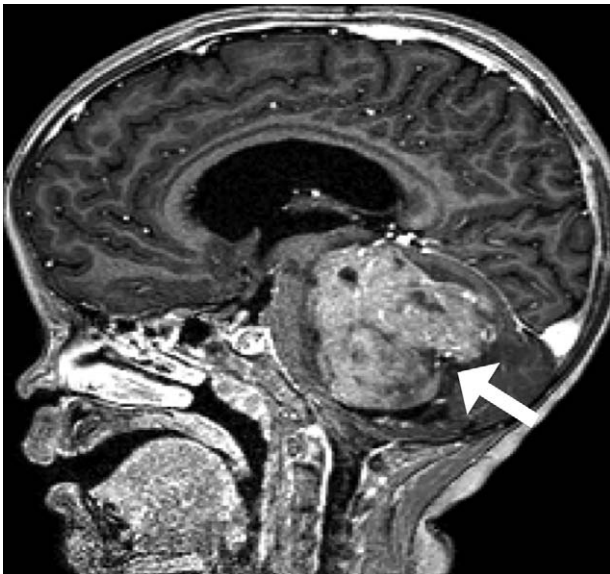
Young male child with Gorlin-Goltz syndrome and positive family history for basal cell carcinoma. Sagittal contrast-enhanced T1-weighted image shows macrocephaly associated with an intensely enhancing cerebellar mass (white arrow) compatible with medulloblastoma.
